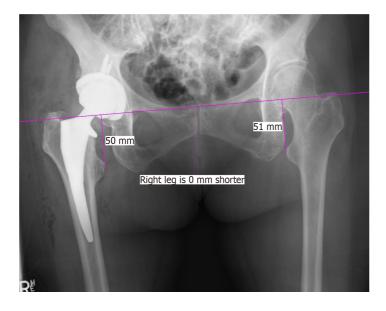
Post-operative x-ray image capture. Representative image of observer obtained leg length discrepancy measurements on a corresponding postoperative anterior-posterior x-ray of the pelvis. Single line drawn through bilateral radiographic teardrops with perpendicular lines to the medial prominence of bilateral lesser trochanters.
